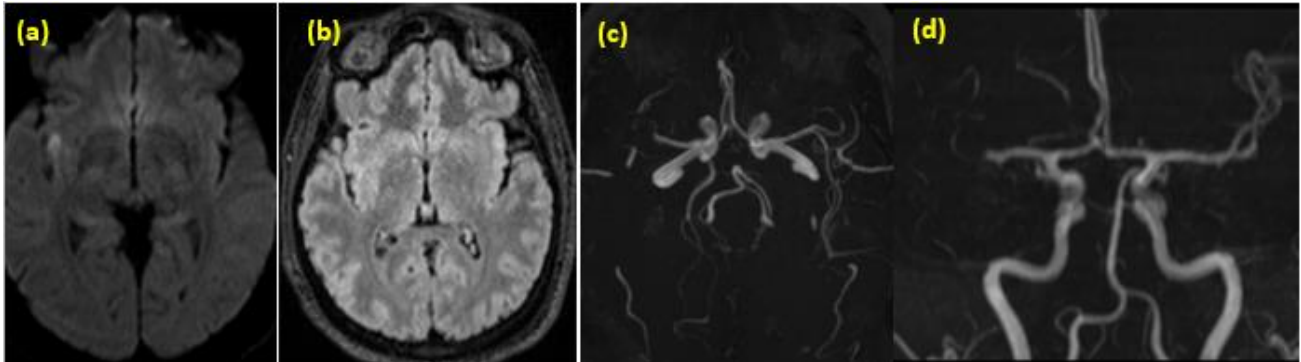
Brain MRI performed 6.5 hours after symptom discovery: (a) diffusion-weighted imaging (DWI) showing acute restricted diffusion in the right insular cortex, (b) axial fluid-attenuated inversion recovery (FLAIR) sequence showing subtle corresponding hyperintensity, and (c-d) magnetic resonance angiography (MRA) demonstrating persistent distal M1 occlusion of the right middle cerebral artery
